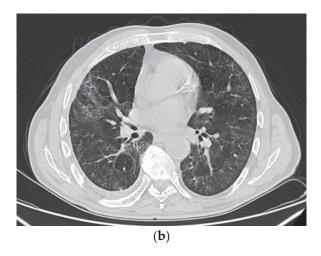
Courtesy of Dr Oana Cristina Arghir, who provided images of post-COVID-19 pulmonary fibrosis from Pneumology Hospital of Constanta, Romania. Thoracic CT scan of a patient with PCF, one year after the acute episode, showing subpleural and peribronchovascular reticular opacities, traction bronchiectasis (a), and GGO bilateral and fibrotic lines predominantly in the upper lobes (b), in a 77-year-old male, with history of severe COVID-19 in October 2021 and PCPF in October 2022.
